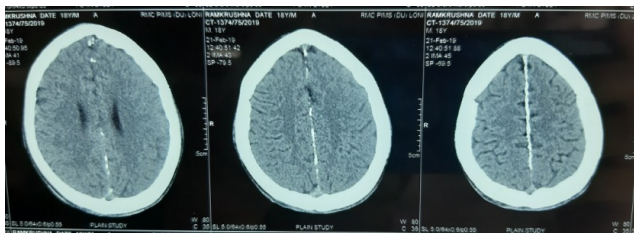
Calcification of falx cerebri in computed tomography scan
